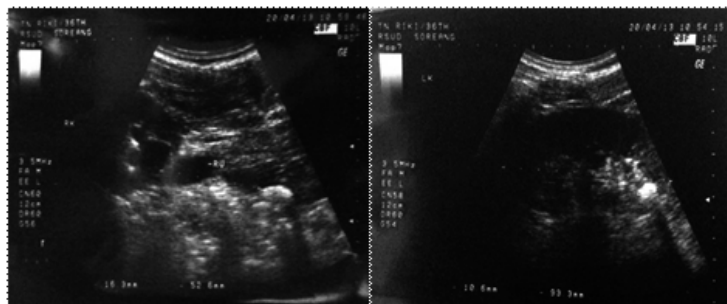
Ultrasonography showing stones at right upper ureter and left kidney
